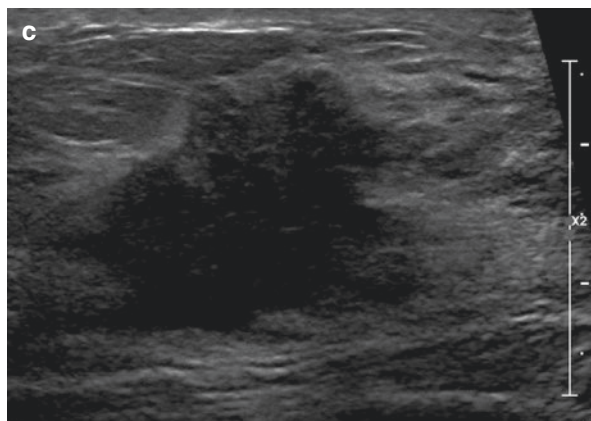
Lowered sensitivity of the detection of masses in extremely dense breast tissue. 40-year-old woman with family history of premenopausal breast cancer. (a) Standard and (b) spot compression views done for a “lump” in the left breast (marked with a metallic BB on the skin) do not clearly show a mass. (c) Targeted ultrasound demonstrates an irregular mass, biopsy of which yielded invasive ductal carcinoma, high nuclear grade
